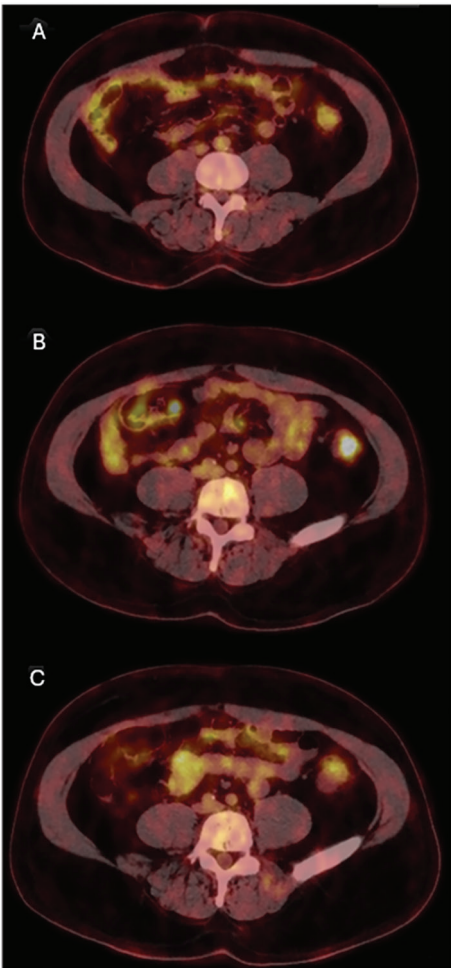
PET/CT images showing metabolic response of peritoneal and rectus muscle implants before regorafenib initiation (A), at 5 months (B), and at 10 months (C) of pembrolizumab + regorafenib therapy.
